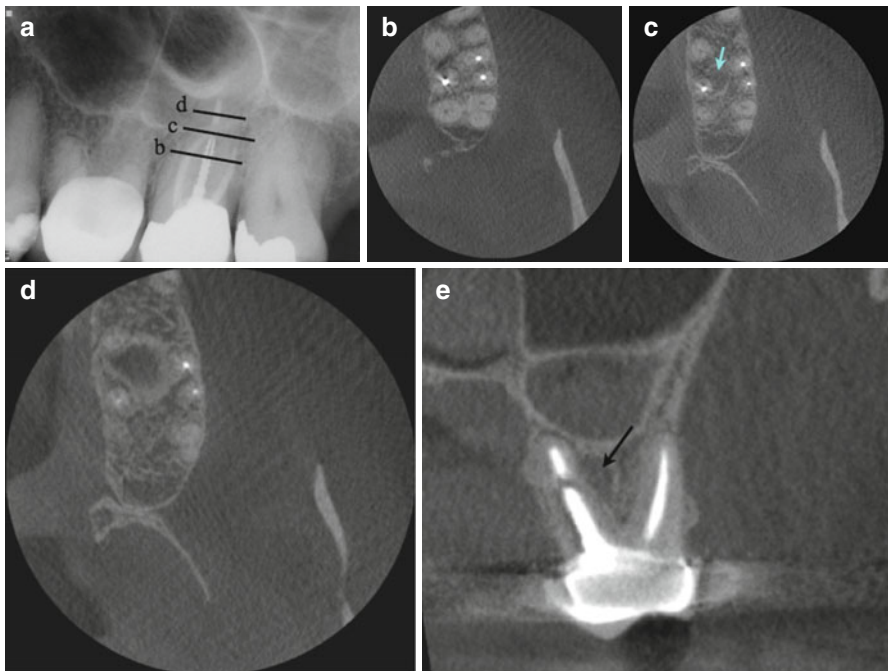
(a) Periapical radiograph of tooth number 14. The three *lines* correspond to the axial section views in (b), (c), and (d). Note mid-root radiolucency (c) in relation to the palatal root at the apical level of the post (*blue arrow*). Intact palatal bone was observed coronal and apical to the mid-root level (b, d). (e) Coronal view showing the distal-buccal and palatal roots of number 14. The *arrow* demonstrates the lateral radiolucency in relation to the palatal root. Vertical root fracture of the palatal root was determined and patient was referred for extraction
